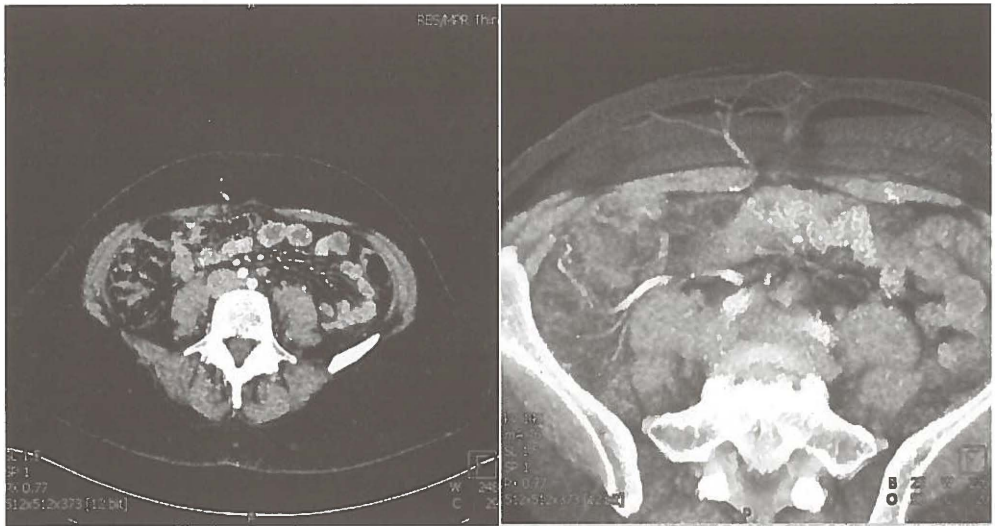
Two CTA images of the same patient. The direction of viewing is from caudal to cranial. a) A 2D reconstruction, which was initially used. Two parts of the perforator can be seen in the subcutaneous tissue just above the right rectus muscle. The reconstruction can be viewed in three planes. b) A 3D reconstruction at a slightly lower level. The perforator and its branching pattern can be seen. In this case there is a branch to the contra lateral side as well. The reconstruction can be viewed from every direction.
